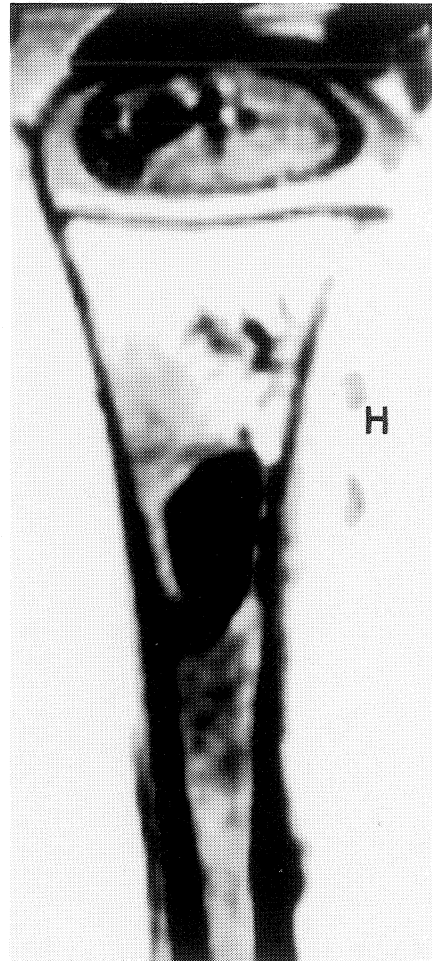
T2-weighted (SE 2000/80) coronal magnetic resonance image of a lamb proximal tibial epiphysis in vitro after heat-killing. Changes are again greatest in the marrow which shows increased signal intensity when compared to the image obtained before heating. There is less change in the epiphyseal cartilage and least in the physis when compared to Figure 7. The dark region in the metaphyseal-diaphyseal junction is again an artifact due to air.
